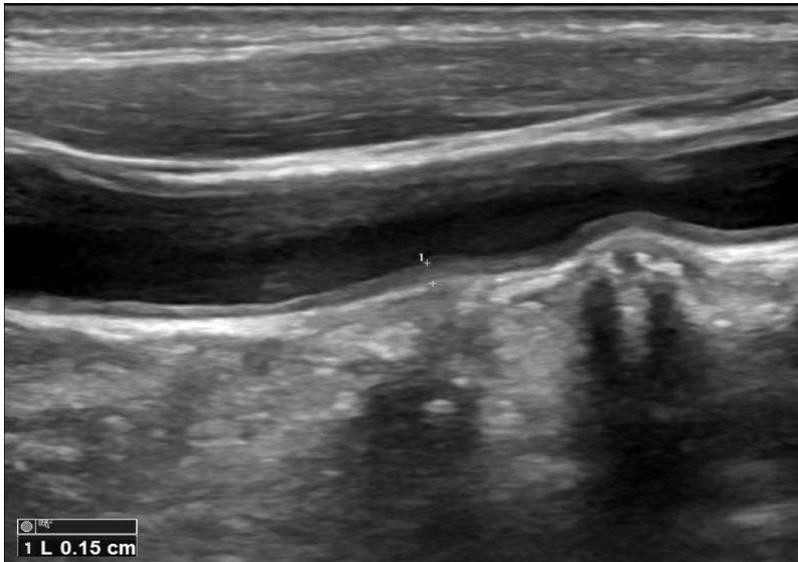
Ultrasonographic longitudinal scanning of the right common carotid artery showed IMT is 1.5 mm (the distance between the marks + and 1+) in a 42 years old BD patient with increased serum endocan level (in 4th quartile). IMT: Intima media thickness; BD: Behçet disease.
